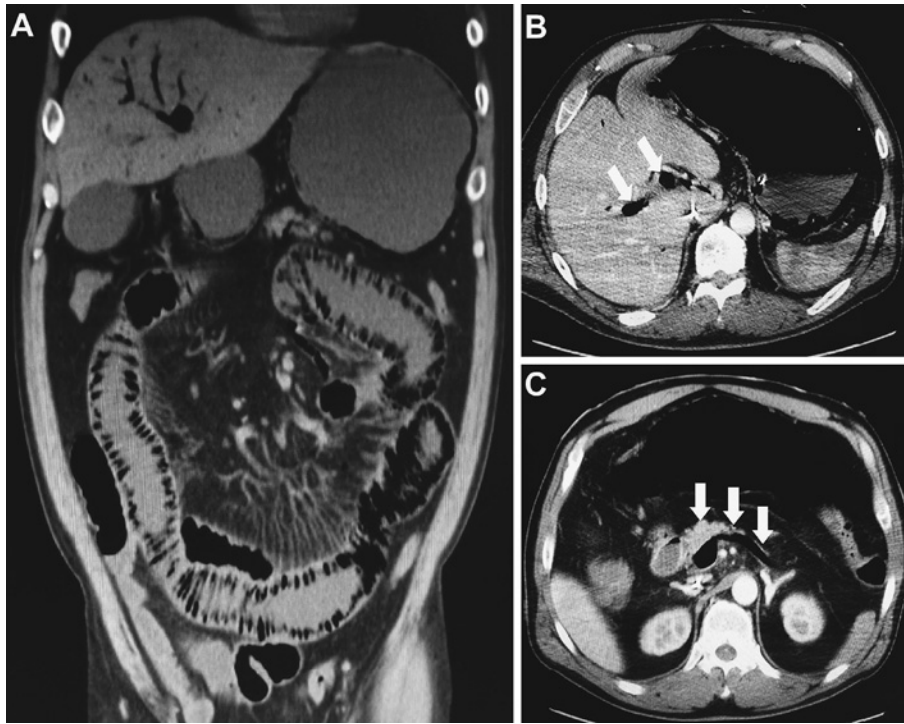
CT scan of a patient with portal venous gas. a: A coronal CT scan showed portal venous gas (PVG) in the liver and pneumatosis intestinalis (PI) throughout the stomach and small intestine. b: An axial CT scan showed PVG in the right and left portal vein (white arrows). c: Air is present in the extrahepatic portal vein and splenic vein (white arrows). This patient underwent emergency laparotomy; however, bowel resection was not needed. He was discharged from our hospital.
